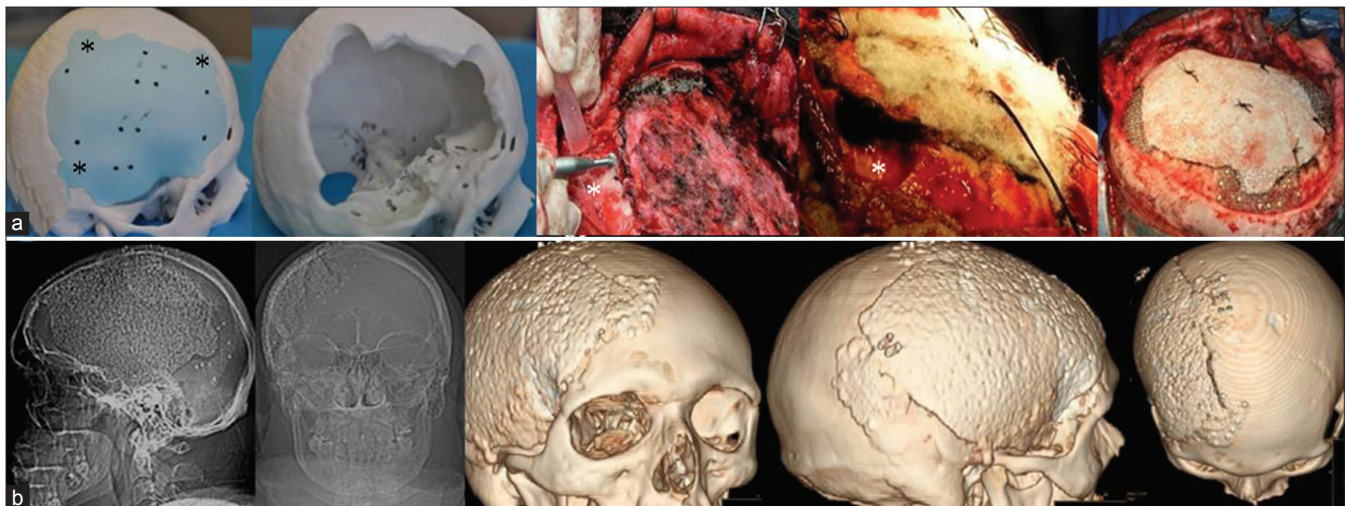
3D implant model showing the extensions (black asterisks) and intraoperative images demonstrating the areas of drilling (white asterisks) and the final implant position (a), CT scan with 3D reconstruction showing the filling of the cranial defect (b)
